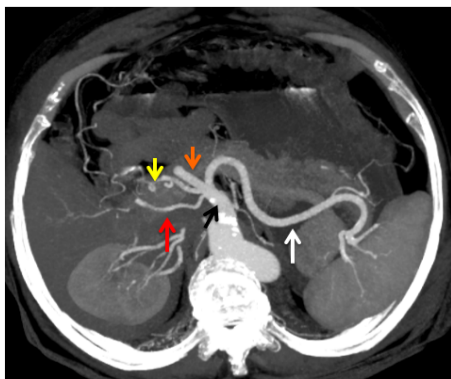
Axial MIP image shows accessory RHA (Red arrow) and LHA (Yellow arrow) originating from CT (Black arrow). CHA (Orange arrow) & SA (White arrow).
